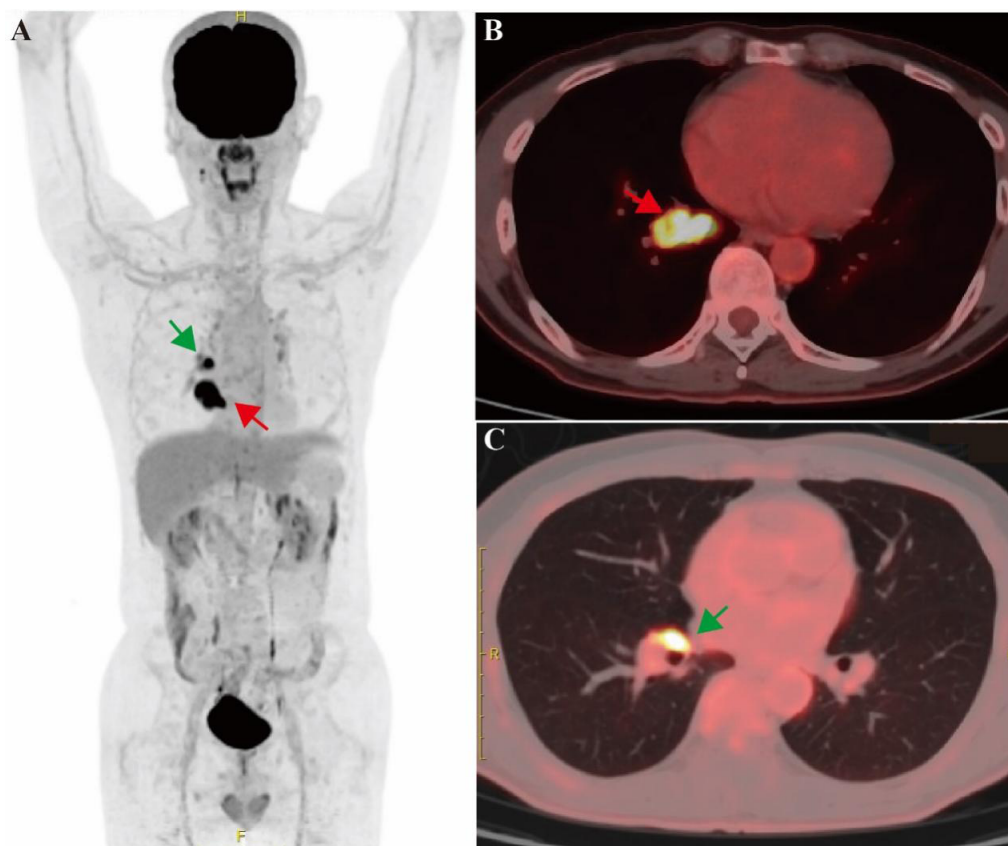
Whole-body 18F-FDG PET image showing increased FDG uptake in the mass (red arrow) and the lymph node (green arrow).
